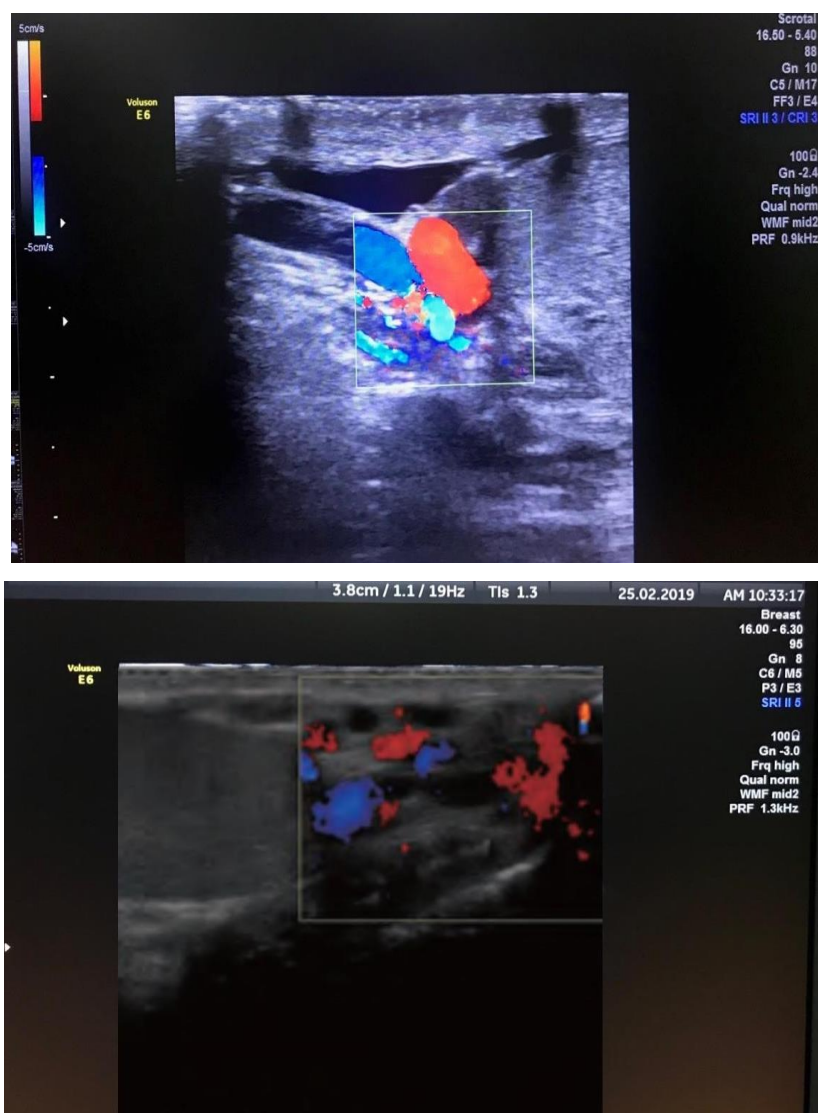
color Doppler ultrasound image of varicocele.
